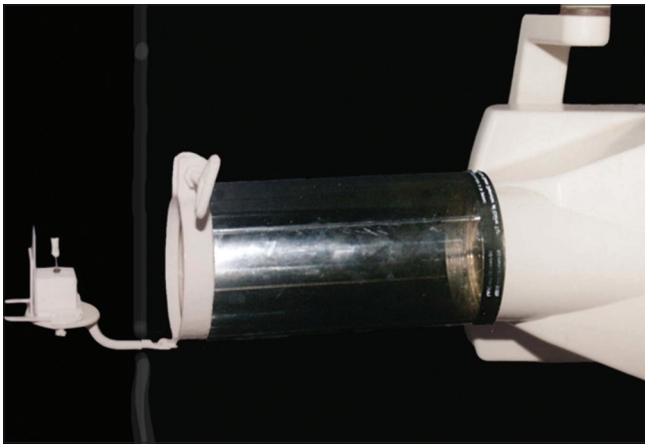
Working length determination by radiographic method
